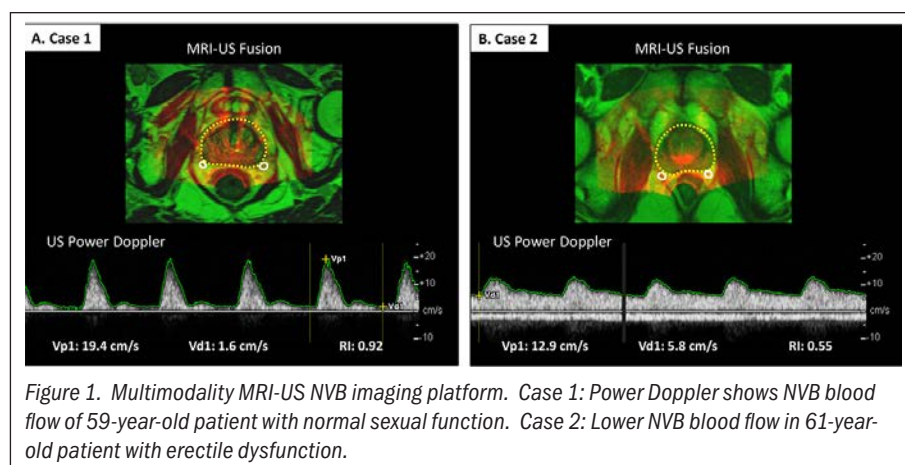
Multimodality MRI-US NVB imaging platform. Case 1: Power Doppler shows NVB blood flow of 59-year-old patient with normal sexual function. Case 2: Lower NVB blood flow in 61-year-old patient with erectile dysfunction.
